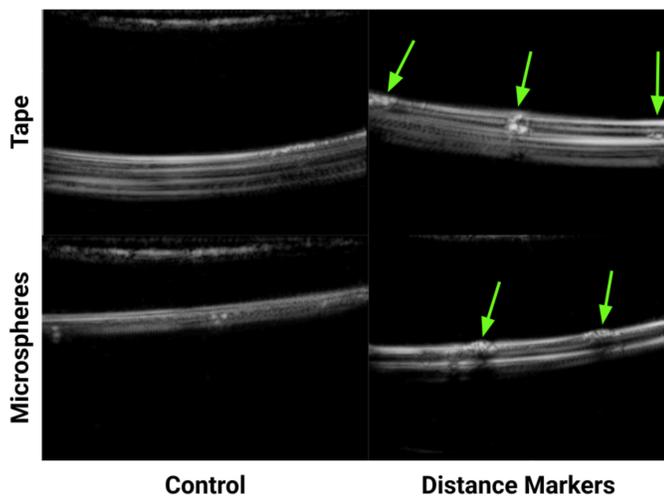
Ultrasound Images of Experimental Conditions applied to standard UVCs. Foam material and Microsphere-Urethane coating were applied to a standard UVC. The applied material is seen on the catheter body (as indicated by the arrows).
